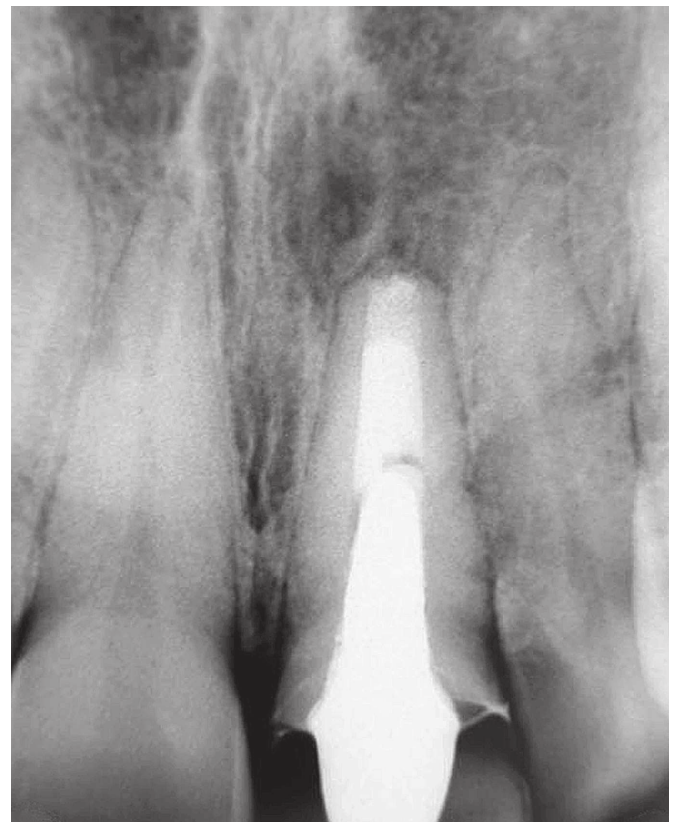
Follow-up periapical radiograph after eight years.
